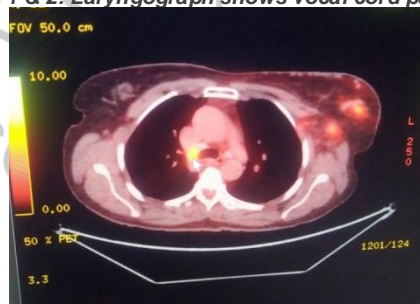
PET CT scan shows hypermetabolic lesions in left breast axillary and mediastinal lymph nodes.
